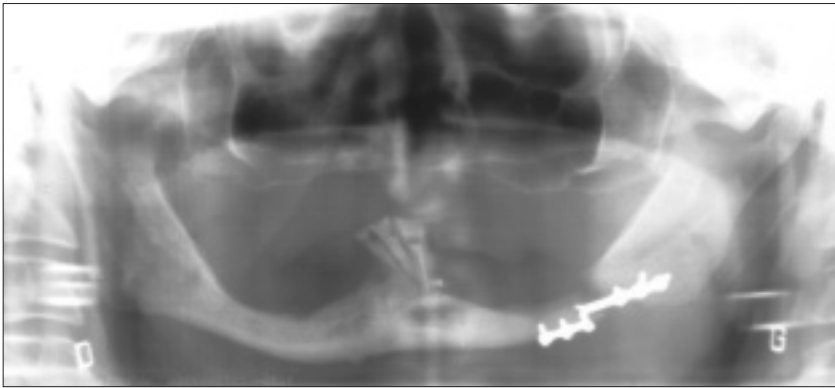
Panoramic radiograph of the patient 3 weeks after fracture reduction shows miniplate fracture.
